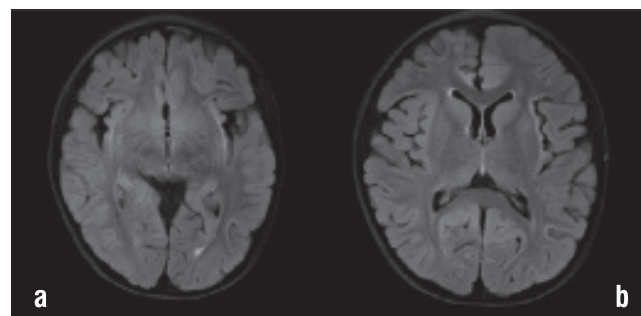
a, b) Axial FLAIR images (repetition time/echo time; 3000/100 ms) performed 3 months later indicated hyperintense areas in both insulae and frontal lobes
